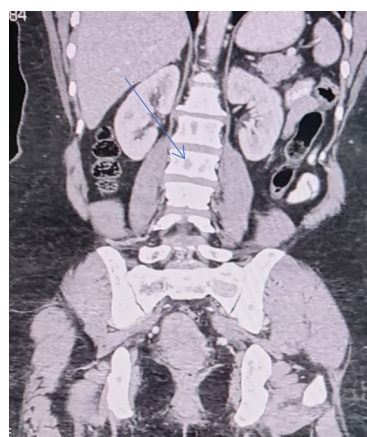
CT scan chest abdomen coronal section; Hypodense areas noted in the Lumbar vertebrae, visualized liver is grossly normal, stomach & rest of the visualized bowel are grossly normal, kidney are grossly normal
